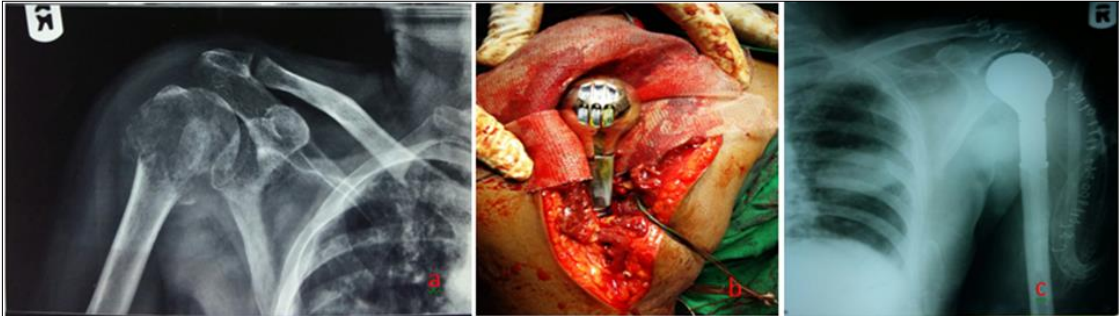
(case with mesh); (a)Pre operative X-ray, (b) Intra operative photograph, (c) Post operative X-ray
